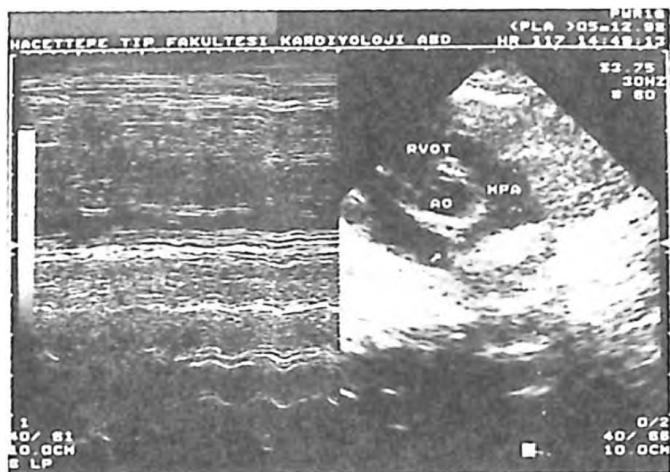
Parasternal short-axis view showing the right ventricular outflow tract (RVOT) and the pulmonary artery branches after correction (MPA: main pulmonary artery, LPA: left pulmonary artery, RPA: right pulmonary artery, Ao: aorta).
